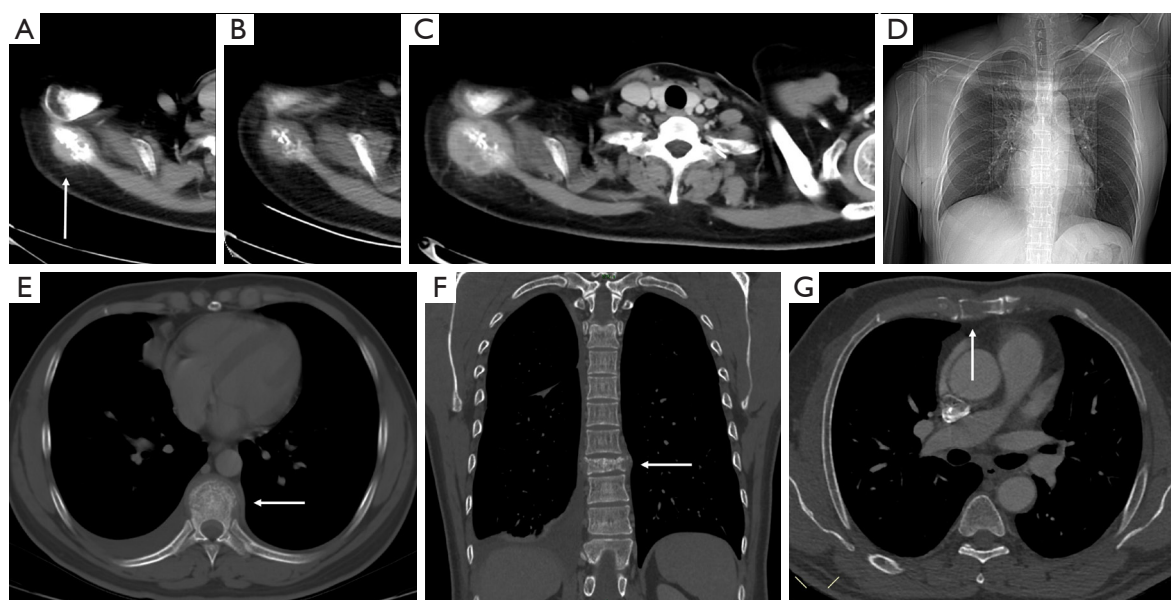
Blind spot on chest CT: bone. (A-D) A 44-year-old female with thymic squamous carcinoma. Metastasis to the right scapula (arrow) was neglected on CT. Retrospective observation revealed progressive bone destruction and enlargement of the soft tissue mass. Despite a lack of relevant clinical information on the requisition form, the patient's inability to elevate her right arm (D, CT scout image) emerged as a crucial indicator of right shoulder disease. (E,F) A 33-year-old male with adenocarcinoma of the right lung and multiple metastases. Radiologists ignored vertebral metastasis with surrounding soft tissue swelling (arrow). A clearer depiction was obtained with the MPR of the coronal plane, revealing vertebral bone destruction and compression fractures (arrow). (G) Radiologists failed to identify sternal metastasis on chest CT (arrow). CT, computed tomography; MPR, multiplanar reconstruction.
